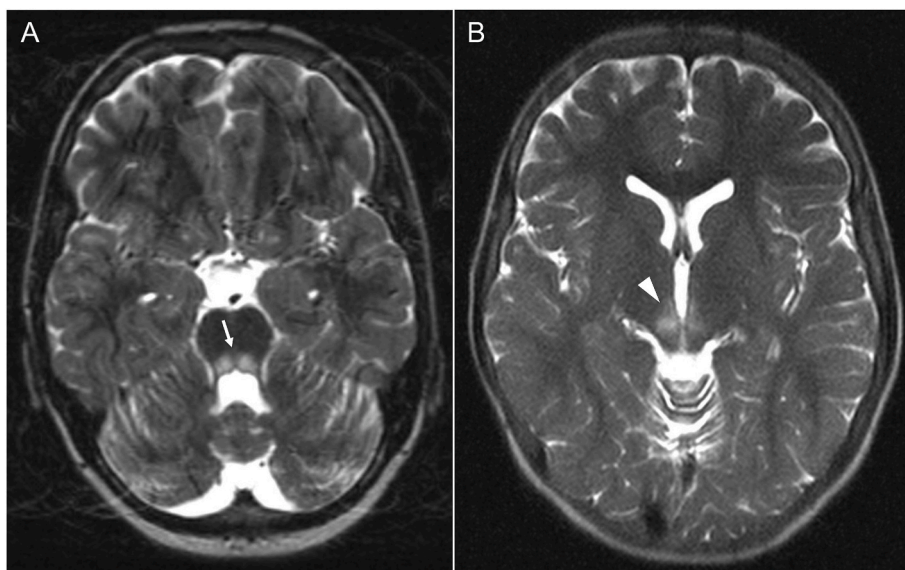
MRI brain with intravenous contrast four days after symptom onset
